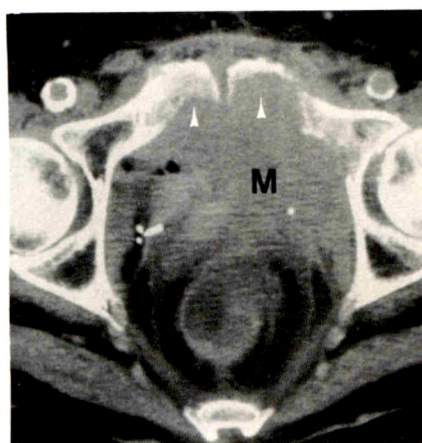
Local tumor recurrence with direct extension into bone after cystectomy in an 81-year-old man. CT scan shows low pelvic mass (M) with extension into symphysis pubis (arrowheads). Needle biopsy of pelvic mass showed transitional cell carcinoma.
